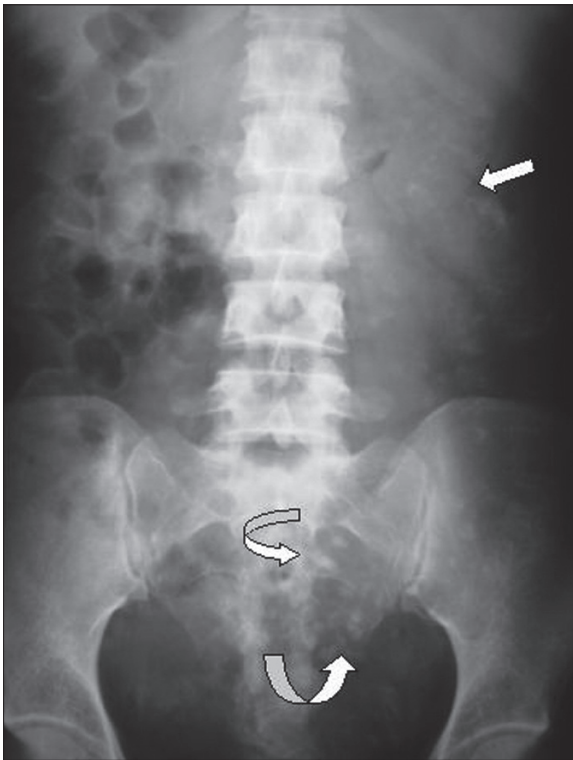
Case 1. Plain x-ray of abdomen: multiple punctate and large calcifications along colonic wall (straight arrow) and mesocolon (curved arrows).
